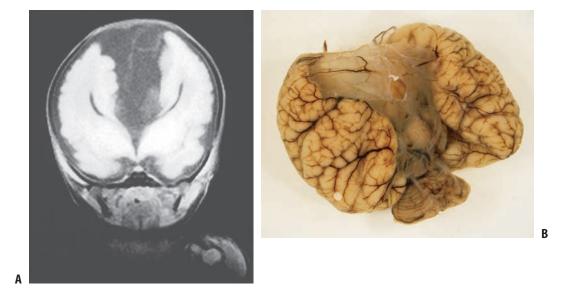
(A) Postmortem magnetic resonance imaging (MRI) scan. An enormous cyst displaces the cerebral hemispheres laterally. (Dr. M. McPhillips, Edinburgh.) (B) Brain after removal from
